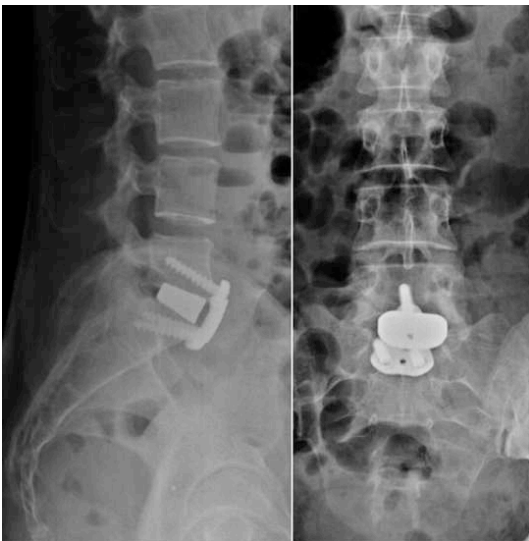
Postoperative x-ray (lateral and AP views) of an L5-S1 ALIF. The patient has been treated with a tantalum cage and a three-screw anterior plate. This construct has the same stability than an anterior cage with four pedicle screws.
